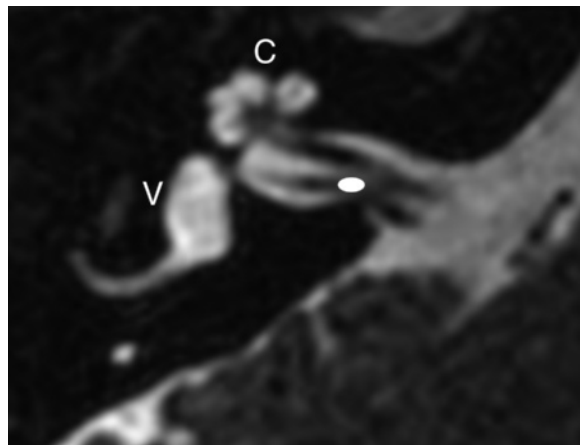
Axial three-dimensional (3D) T2-weighted sampling perfection with application-optimized contrasts by using different flip angle evolutions (SPACE) image shows the vestibular nerve complex. The vestibular (Scarpa) ganglion lies within the shaded oval, where neurons receive input from cochlear hair cells. This region also approximates the location of the Obersteiner-Redlich zone, the transition from the central to the peripheral nervous system. *C* = cochlea, *V* = vestibule.
